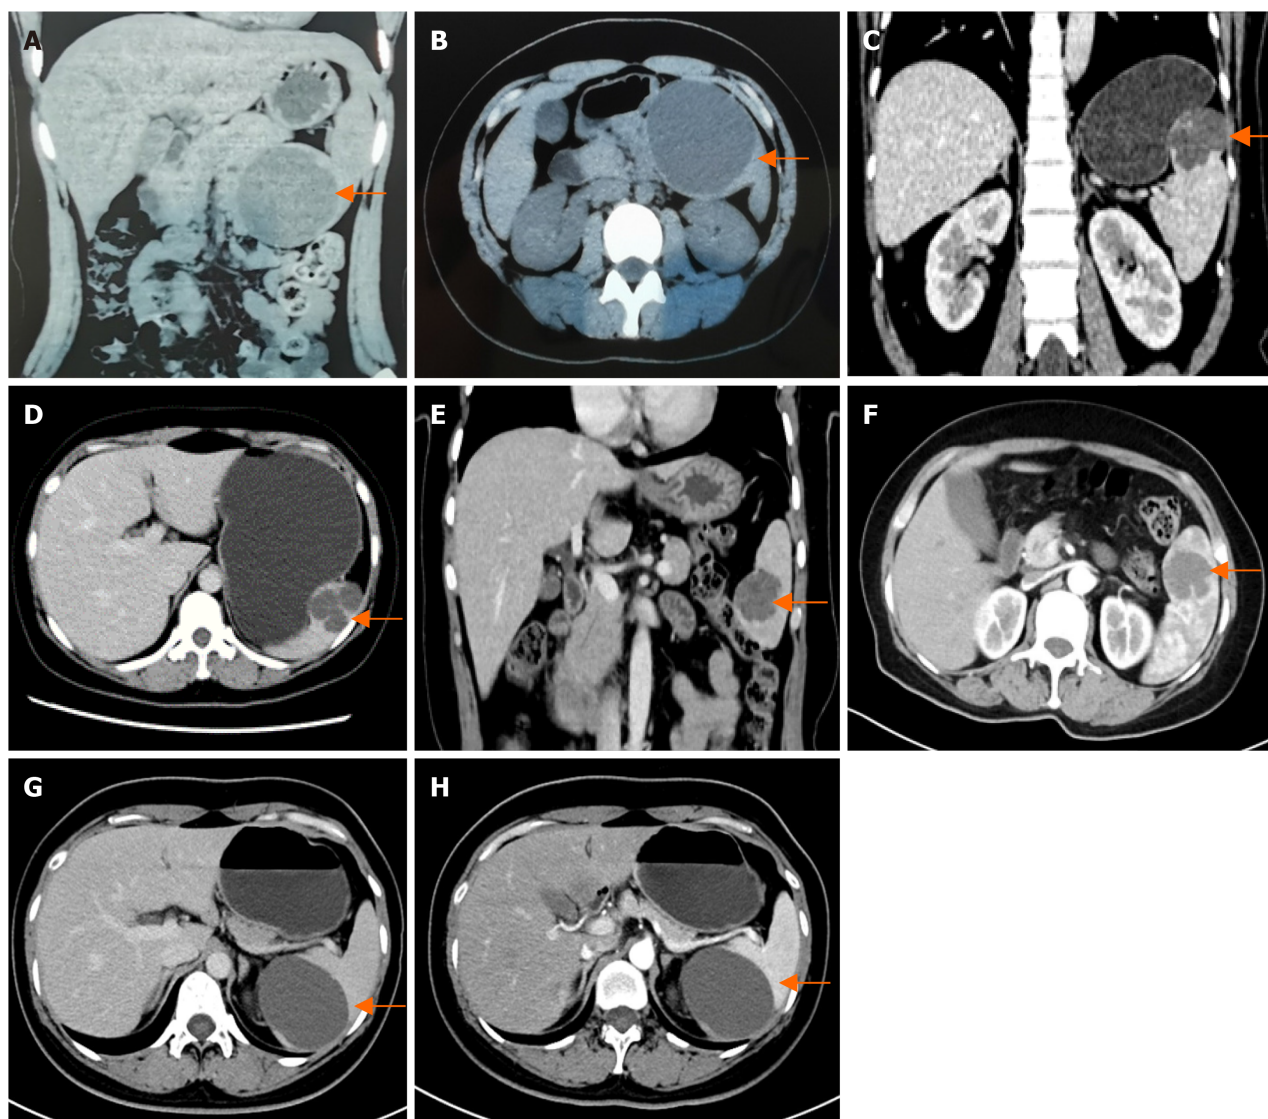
Imaging examinations of four patients. A and B: Computed tomography (CT) revealed a round, non-enhancing low-density lesion measuring approximately 90 mm in the lower pole of the spleen (arrows), which was consistent with a splenic cyst; C and D: CT revealed multiple oval-shaped low-density lesions in the upper segment of the spleen (arrows), with the largest measuring approximately 52 mm; E and F: Magnetic resonance imaging revealed a 40 mm well-defined mass in the lower pole of the spleen (arrows), which appears as a low signal on T1 weight and a high signal on T2 weight; G and H: CT revealed a round, non-enhancing low-density lesion measuring approximately 73 mm in the lower pole of the spleen (arrows).
